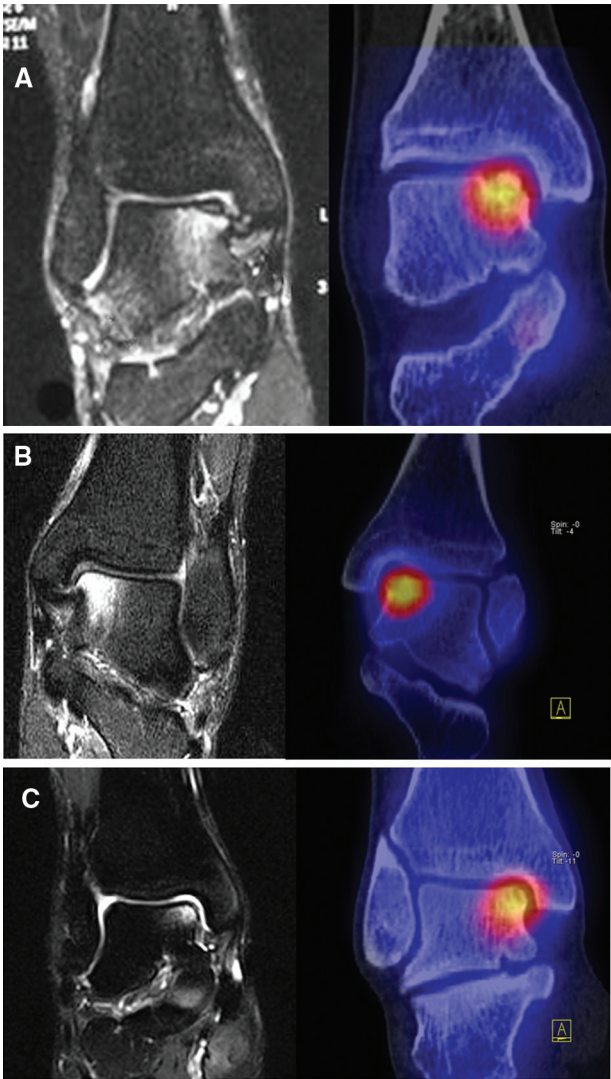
Osteochondral lesion of the talus. Three cases were shown by MRI and SPECT-CT. The different size of bone marrow edema and area of scintigraphic activity is evident in A and B but comparable in C. While the subchondral bone plate is continuous on MRI (A, B), it is interrupted (A) or bulky (B) on SPECT-CT, or the interruption is at another area of the lesion (C).
